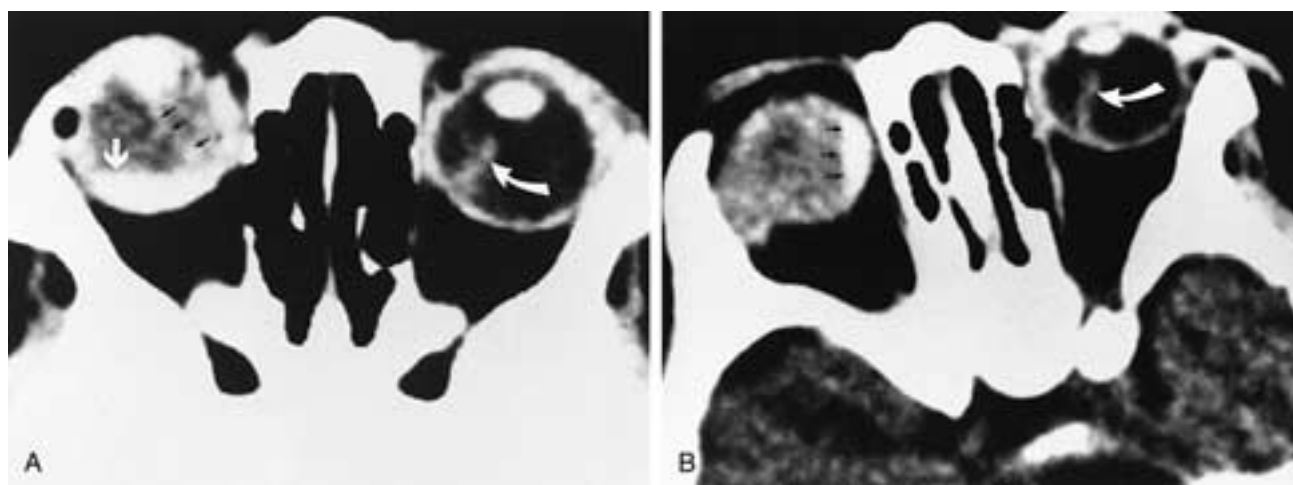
Posterior hyaloid detachment and congenitally nonattached retina. Axial CT scans obtained without contrast in the supine position (A) and the decubitus position (B) show gravitational layering fluid (*white arrow* in A), which is related to hemorrhage in the subhyaloid space. Fluid shifts more freely in the subhyaloid space than in the subretinal space (*black arrows* in B). Note the congenitally nonattached retina of the left eye (*curved arrows*). Increased density, as well as retrolental soft tissue of the right eye (*black arrows* in A), are related to PHPV. (From Mafee MF et al. CT in the evaluation of patients with persistent hyperplastic primary vitreous [PHPV]. Radiology 1982;145:713–717.)
